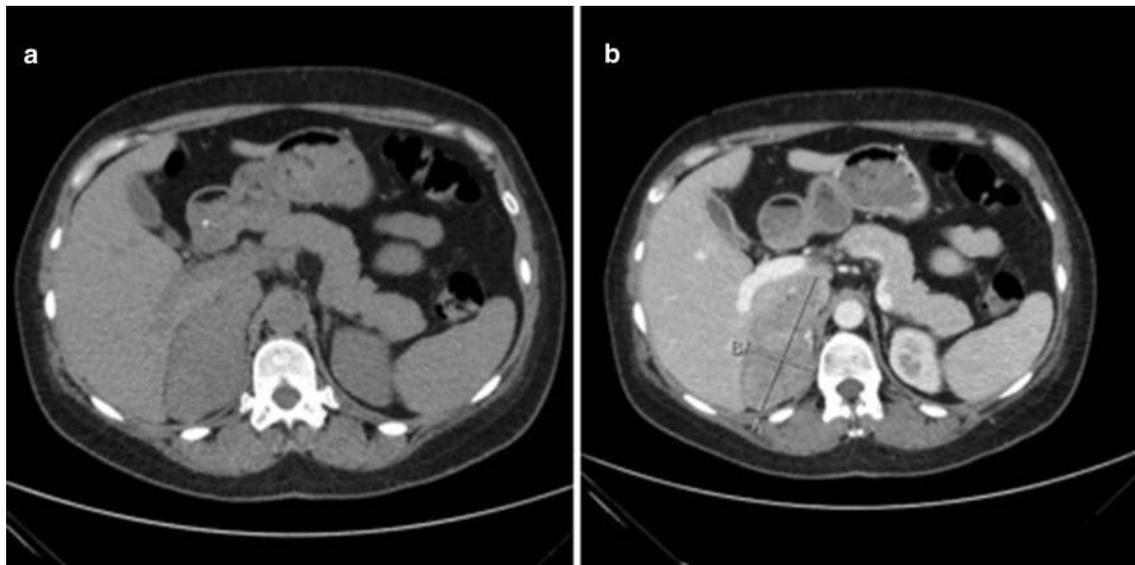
a Precontrast and b postcontrast computed tomography in a 45-year-old female with Cushing's syndrome and adrenocortical carcinoma. Imaging reveals a heterogeneously enhancing right adrenal mass with irregular margins and tumor thrombus extension into the inferior vena cava
